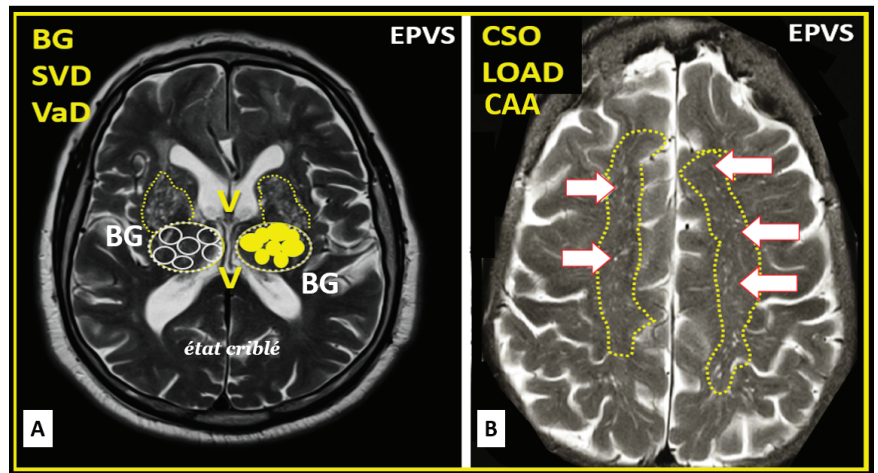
Magnetic resonance imaging (MRI) identification and comparison of basal ganglia (BG) to centrum semiovale (CSO) enlarged perivascular spaces (EPVS). (A) Paired EPVSs within the BG that are traced in open circles on the left and solid yellow circles on the right BG. Note the white spaces within the paired dashed lines just above the paired BG structures. MRI image from a 75 year old male post-stroke, recovered with small vessel disease. (B) Paired elongated oval structures outlined by yellow dashed lines to enclose multiple white enlarged perivascular spaces. Note the open white arrows outlined in red pointing to prominent EPVSs. MRI image from a 79 year old female with history of transient ischemic attacks. Importantly, note that BG EPVS are strongly associated with cerebral small vessel disease (SVD) in (A) and that CSO EPVSs are strongly associated with late-onset Alzheimer’s disease and cerebral amyloid angiopathy (CAA) in (B). Incidentally, EPVS are more commonly associated with CSO in atherosclerosis, arteriolosclerosis, obesity, metabolic syndrome, and T2DM. Image reproduced with permission from CC 4.0 [64]. Etat criblé = sieve-like state.
